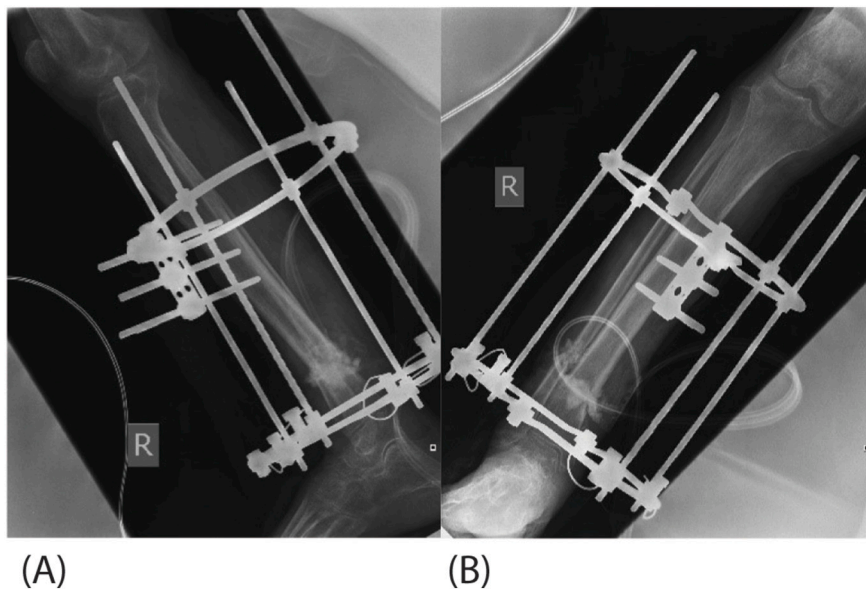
(A) Lateral radiograph post operation: fibular osteotomy with antibiotic loaded bone substitute, application of Ilizarov external fixator. (B) Anterior Posterior radiograph post operation: fibular osteotomy with antibiotic loaded bone substitute, application of Ilizarov external fixator.
